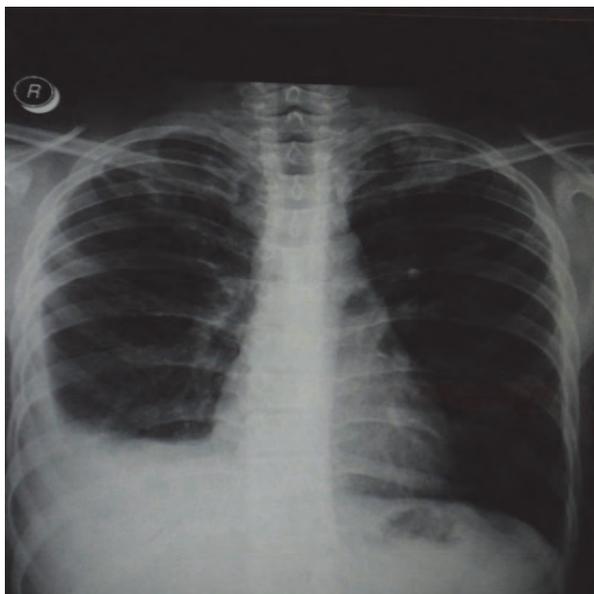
Chest radiography (X-ray) two weeks after the introduction of antituberculosis treatment.
